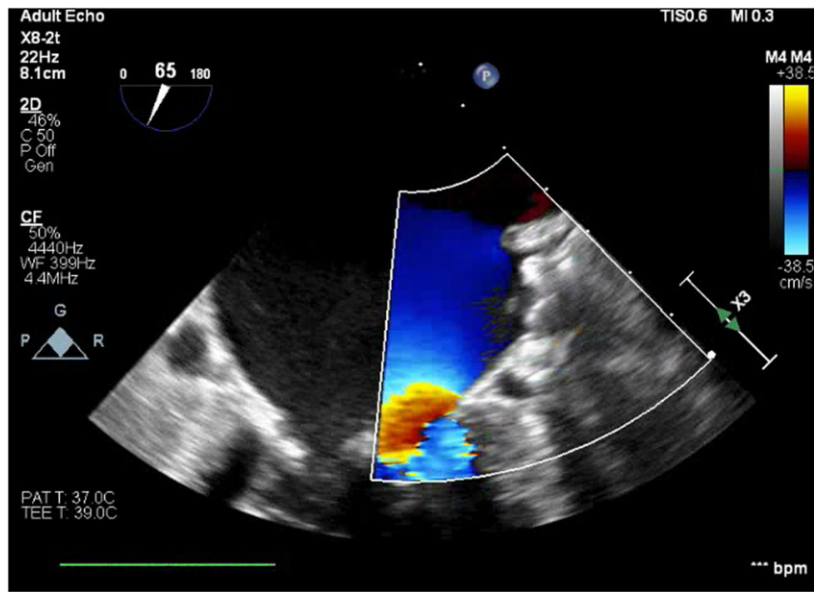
Transoesophageal echocardiography imaging showing left atrium post-successful extraction of thrombus.
